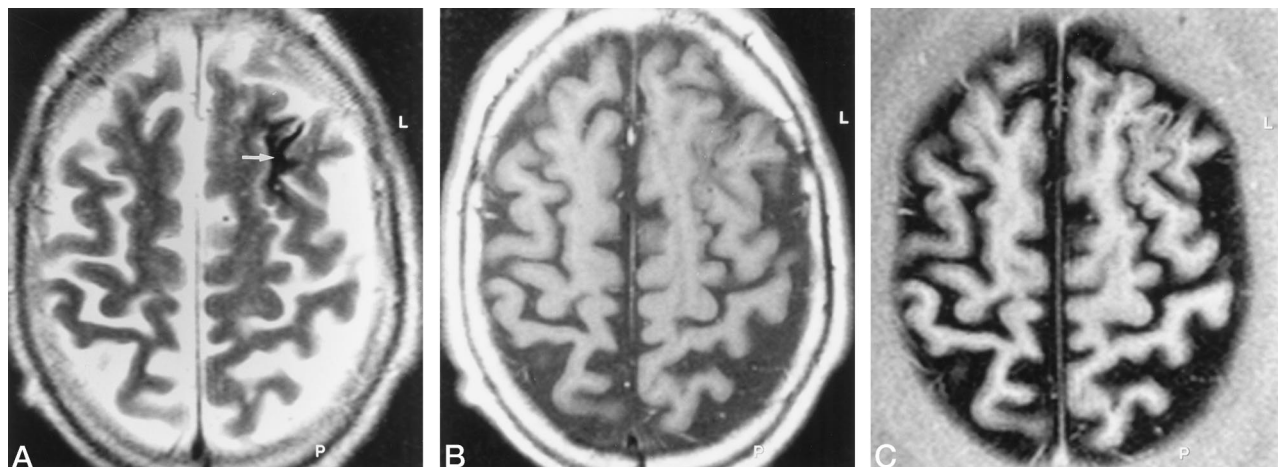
A hypointense gyriform lesion was thought to contain hemosiderin or other cations because of its appearance on the T2-weighted turbo spin-echo study (arrow, A). As expected, this finding was not seen on either the noncontrast T1-weighted spin-echo image (B) or the IR-EPI image (C).
